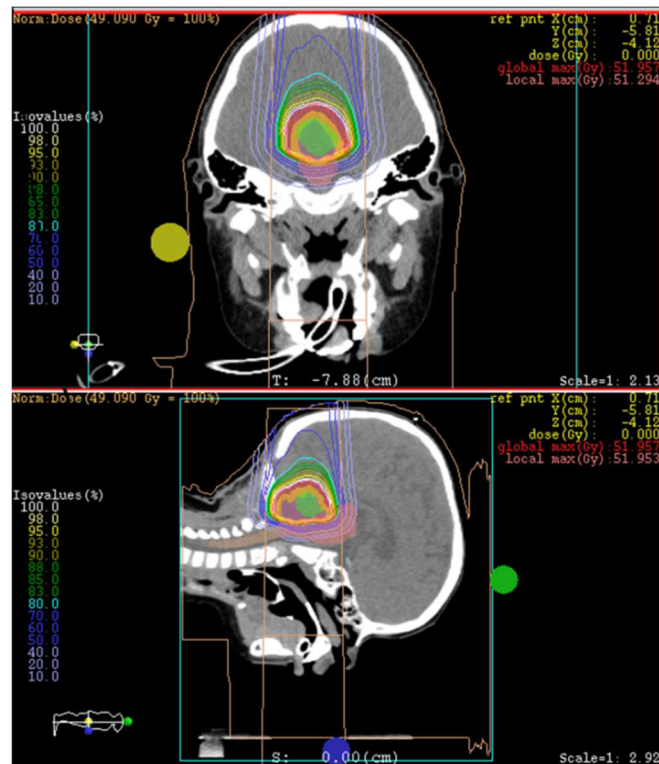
Images from XiO TPS which show the two beams applied to the patient CT and the resulting isodose curves for Plan 2.
